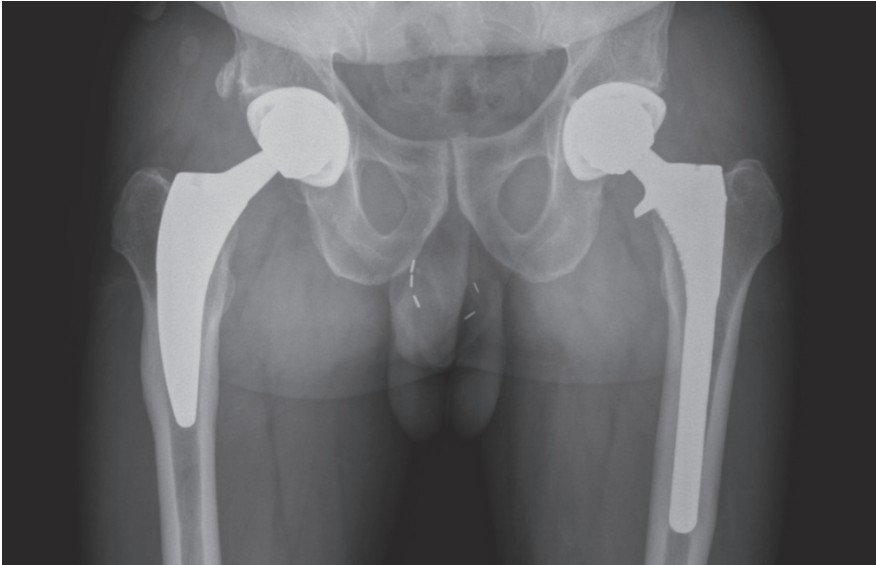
Radiograph of a short-stem and standard-stem total hip arthroplasty
